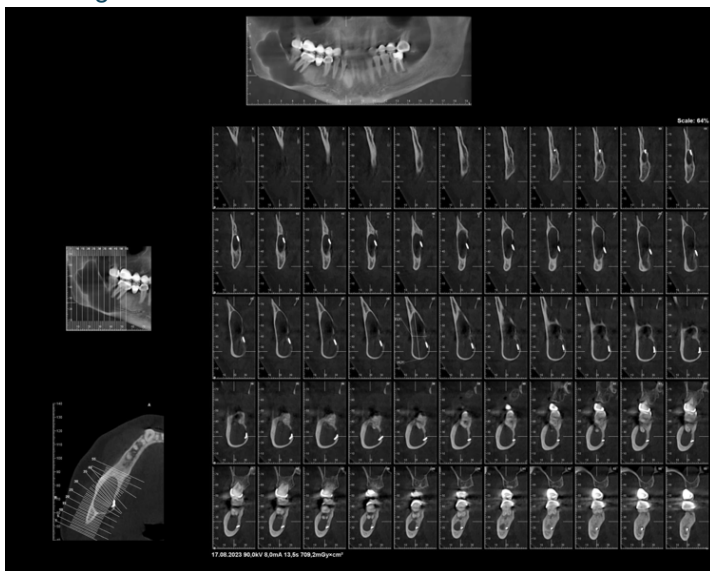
CBCT of the lesion
